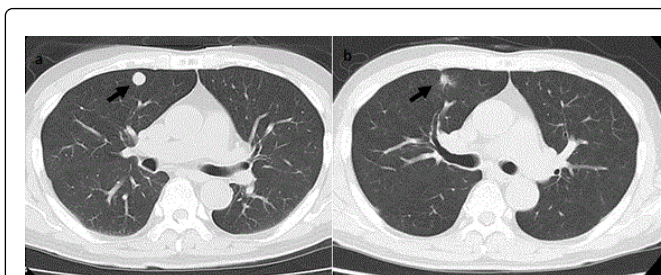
The CT scan findings of a 67-year-old male with lung metastases from UPS in the right thigh: a) before pazopanib treatment, and b) 5 months after pazopanib treatment. The therapeutic efficacy was PR.
